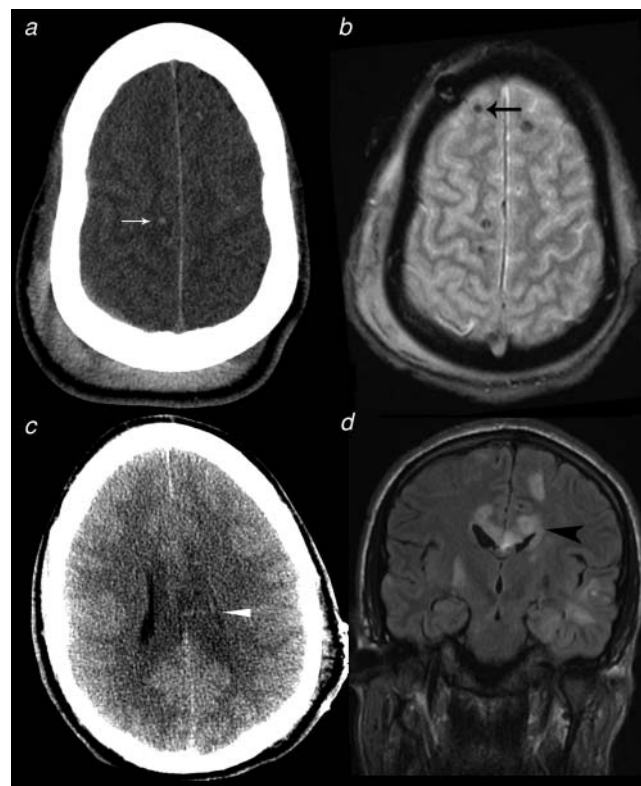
Magnetic resonance imaging (MRI) is more sensitive for detection of shear injuries in diffuse axonal injury. Whereas computed tomography (CT) may reveal characteristically small foci of hemorrhagic shear injury (a, white arrow), gradient echo MRI frequently shows “blooming” foci of low signal, indicating hemorrhagic shear even in locations where the CT scan appears normal (b, black arrow). Similarly, nonhemorrhagic shear injuries are frequently less apparent on CT (c, white arrowhead) than on fluid attenuation inversion recovery MRI (d, black arrowhead).
